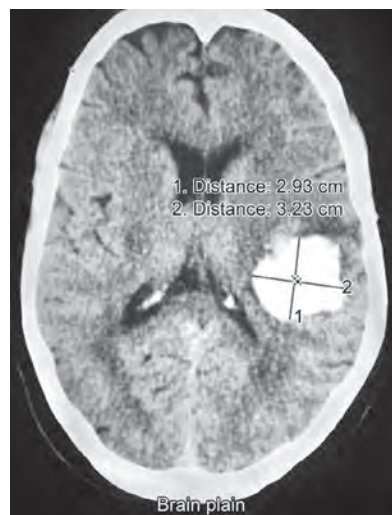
Lobar haemorrhage-CT
